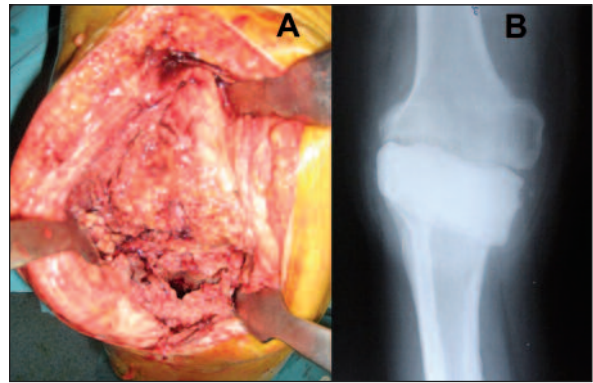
A- Intraoperative photo taken after removal of the prosthetic components and debridement, B- x-ray showing the cement spacer.
